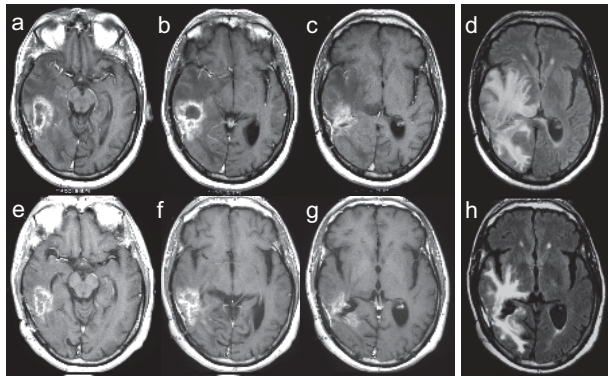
Brain MRI studies of patient 9. Before administration of CpG oligodeoxynucleotide (ODN), gadolinium-enhanced sections (a–c) and fluid-attenuated inversion recovery (FLAIR) sequence (d) showed a recurrent tumor in the right temporal lobe with surrounding edema. Thirty days after administration of CpG ODN, the area of contrast enhancement, the surrounding edema, and the mass effect were reduced at the site of injection (e–h).
